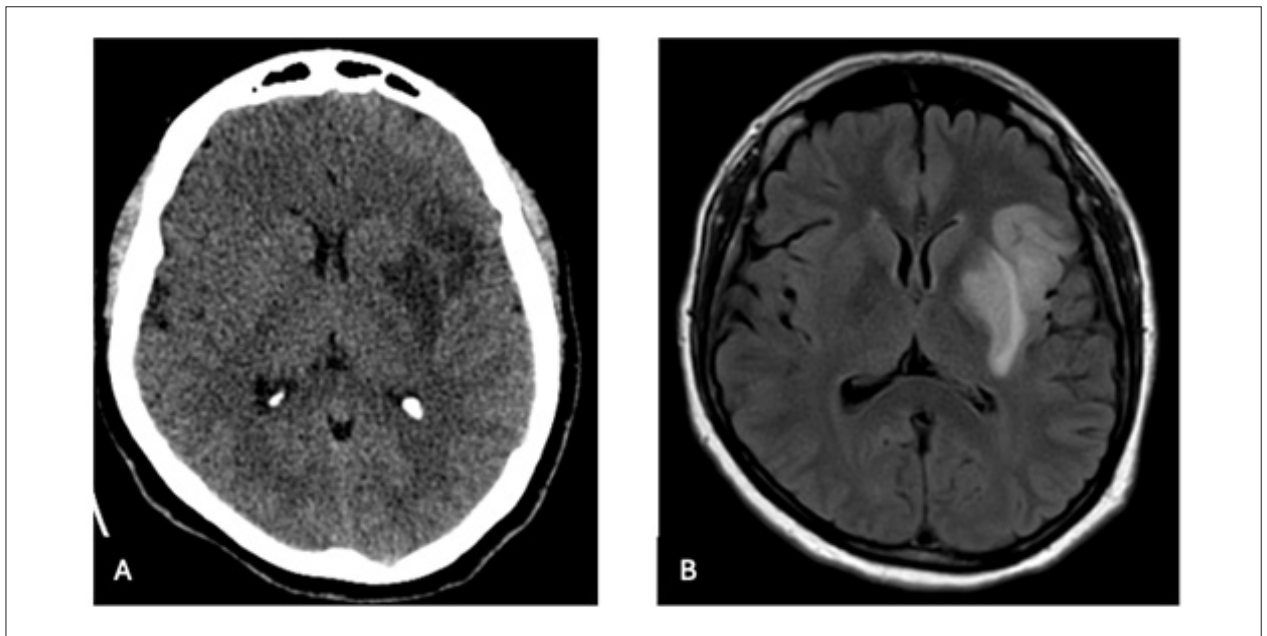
Non-contrast brain computed tomography reveals an ischemic stroke in the middle cerebral artery territory (Image A). Non-contrast brain magnetic resonance imaging in FLAIR sequence confirms a hyperacute ischemic stroke (Image B).
